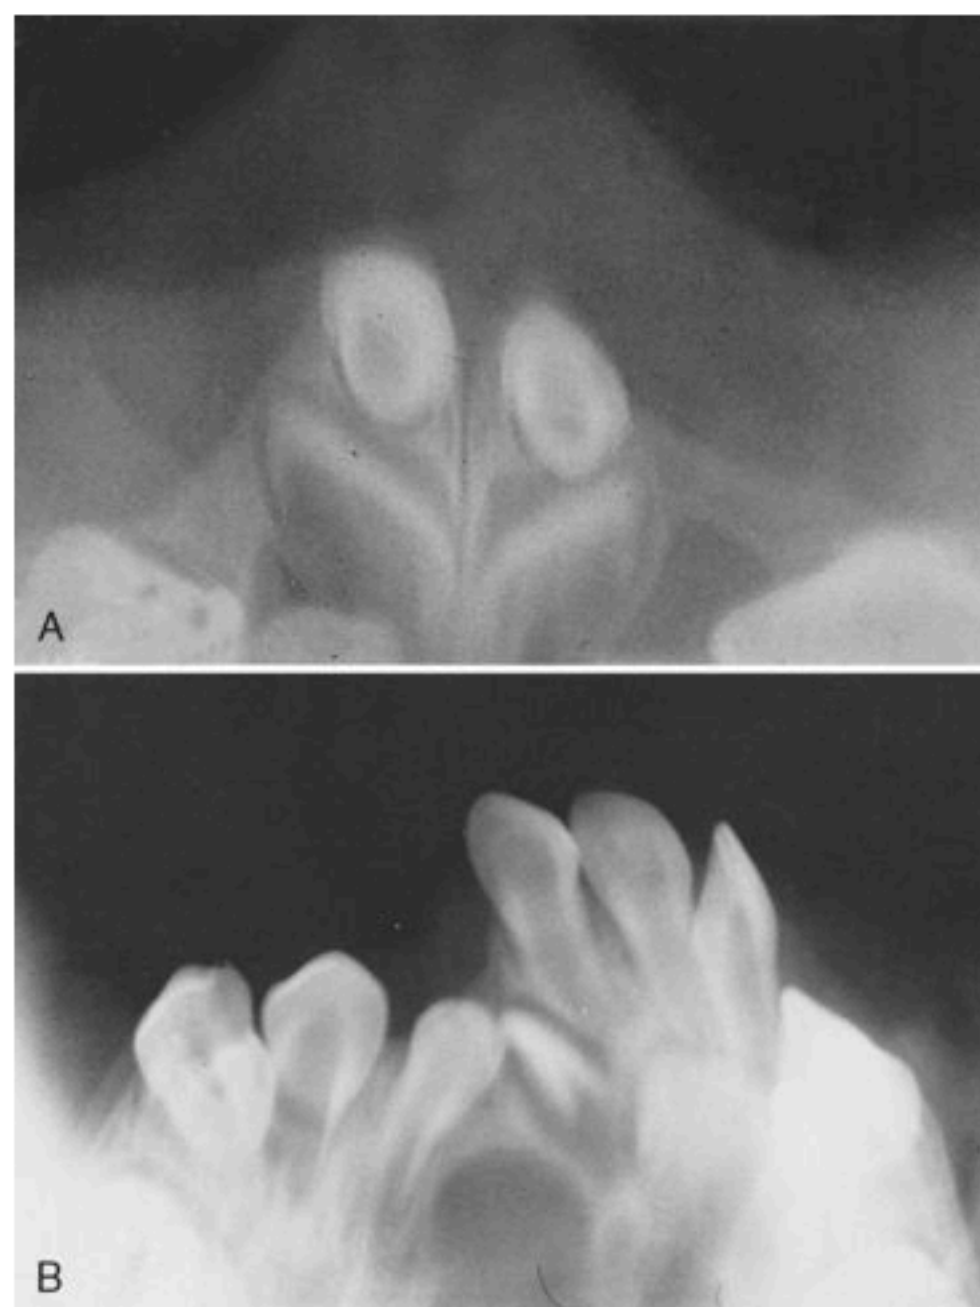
A, Radiograph of bilateral complete cleft of the lip and palate after primary alveolar cleft bone graft. Notice the grafted bone bridging the cleft sites, which provides stabilization of the premaxillary segment. B, Radiograph of unilateral complete cleft of the lip and palate after primary alveolar cleft bone graft. Notice the grafted bone bridging the cleft site and the migration of the primary lateral incisor through the graft.
